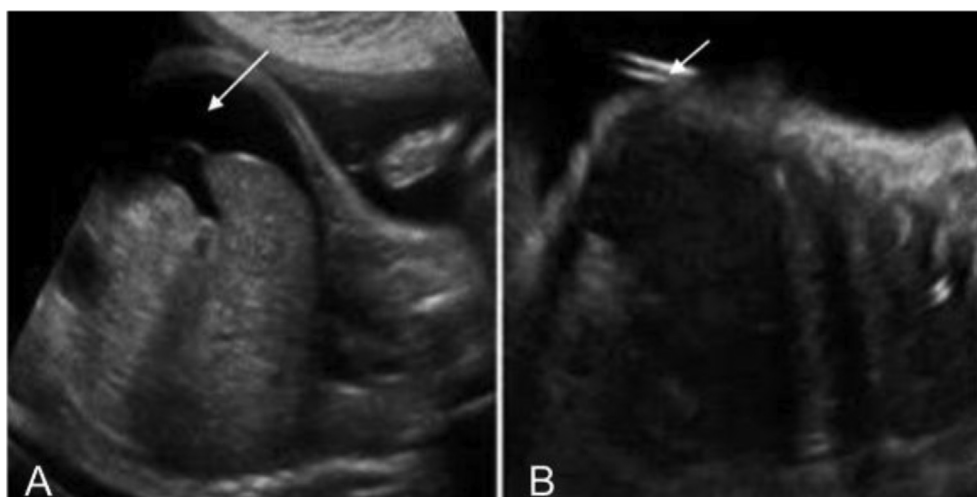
Ultrasound scans during pregnancy. A) Longitudinal view shows ascites (white arrow). B) Longitudinal view shows peritoneo-amniotic shunt and ascites (white arrow).
